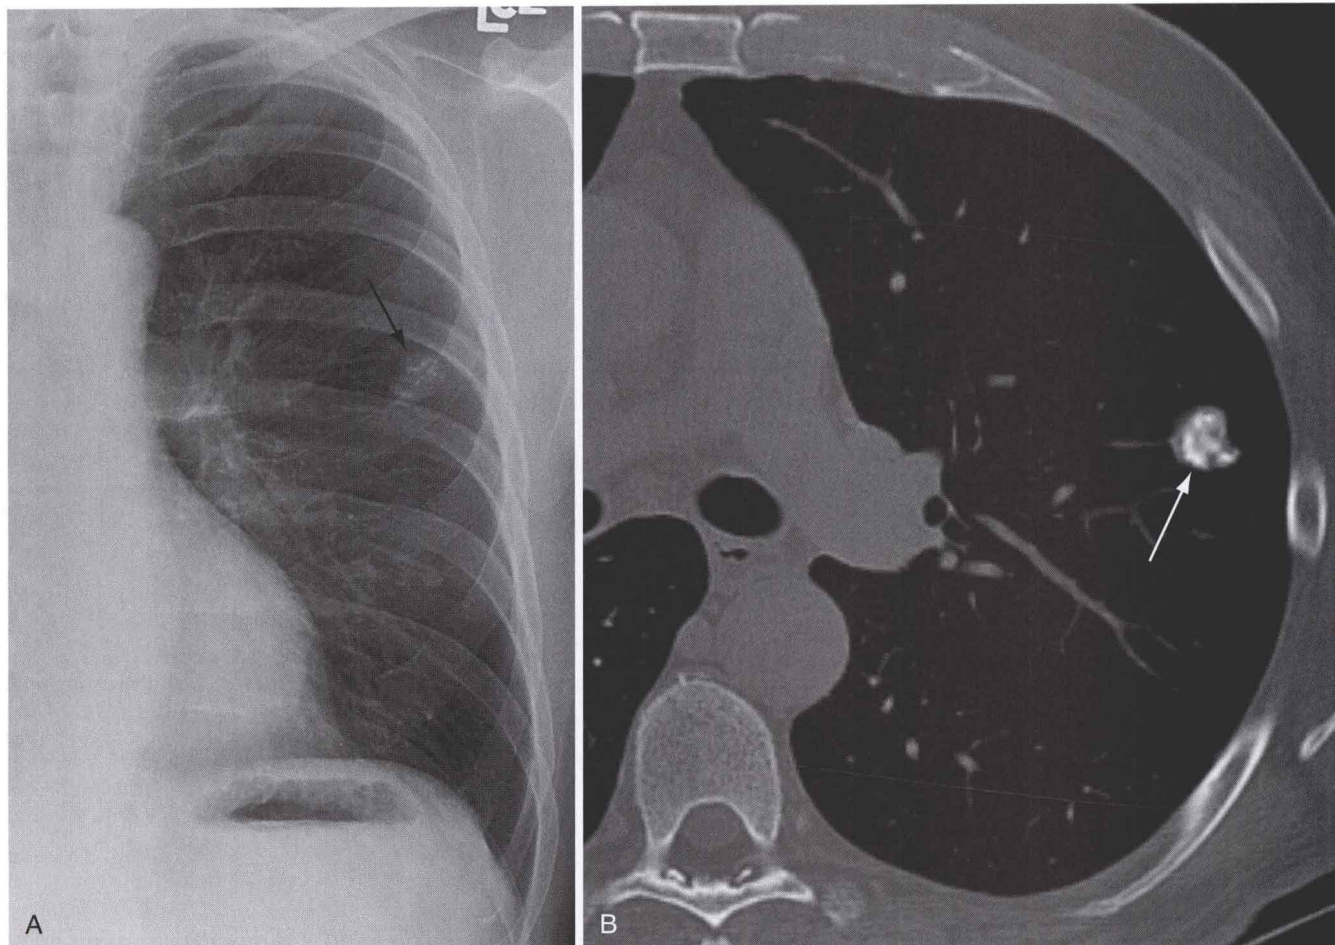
Treated non-small cell lung cancer of the right lung in a 59-year-old man. Left upper lobe nodule shows popcorn-like calcifications (arrow) on the chest radiograph (A) and non-contrast-enhanced chest CT scan (B), consistent with a pulmonary hamartoma. This nodule remained stable at 7-year follow-up evaluation by chest CT (not shown).
